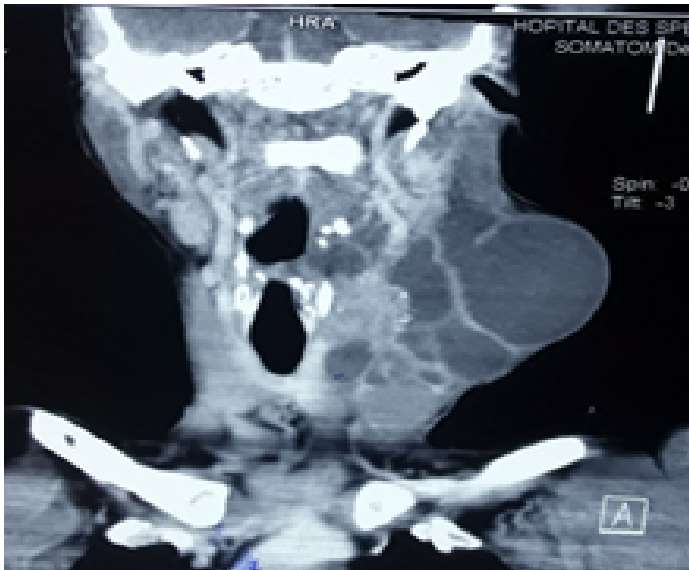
CT-Scan of the cervical mass
